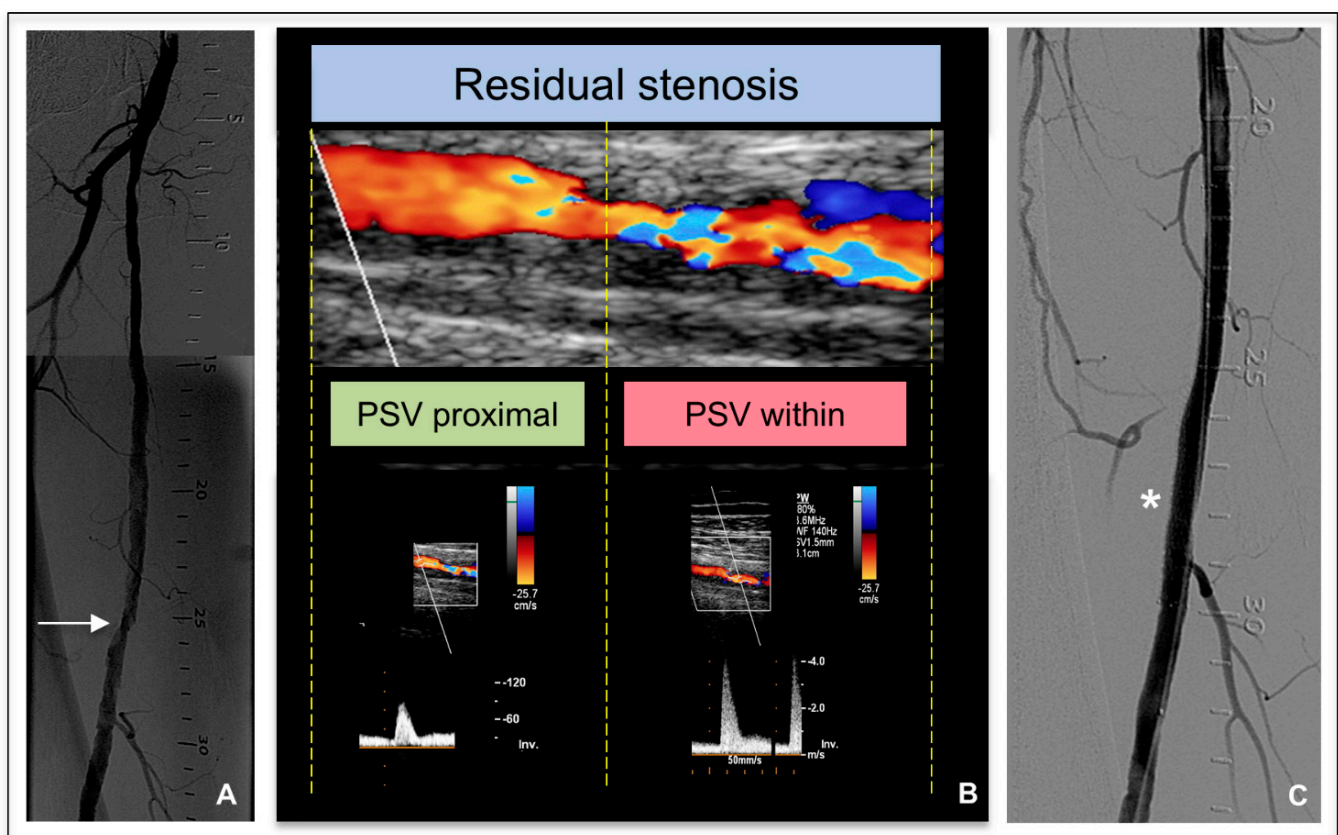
Example of intraoperative DUS assessment of residual stenosis that occurred after PTA of calcified stenosis. (A). Digital subtraction angiography showed intermediate residual stenosis $< 50\%$ (white arrow). (B) Intraoperative DUS showed abnormal PSVR within treated segment. (C) Result after bailout stenting that was necessary to fix persistent lesion recoil despite multiple post-dilatation (white asterisk). DUS = Doppler ultrasound. PSV = peak systolic velocity. PTA = percutaneous transluminal angioplasty.
